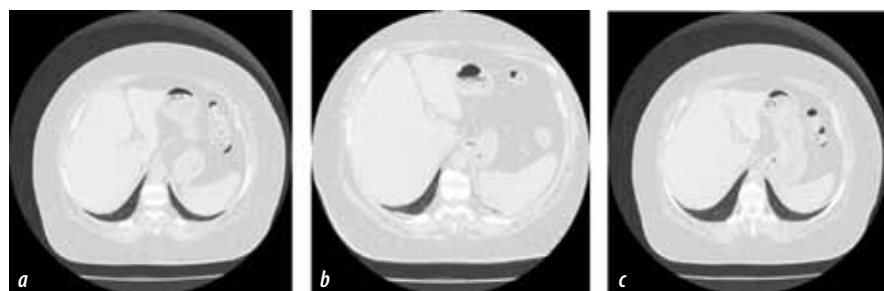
CT scan of a 67-year-old patient upon admission to the hospital with a PCR-confirmed diagnosis of COVID-19 SARS-CoV-2 etiology.
